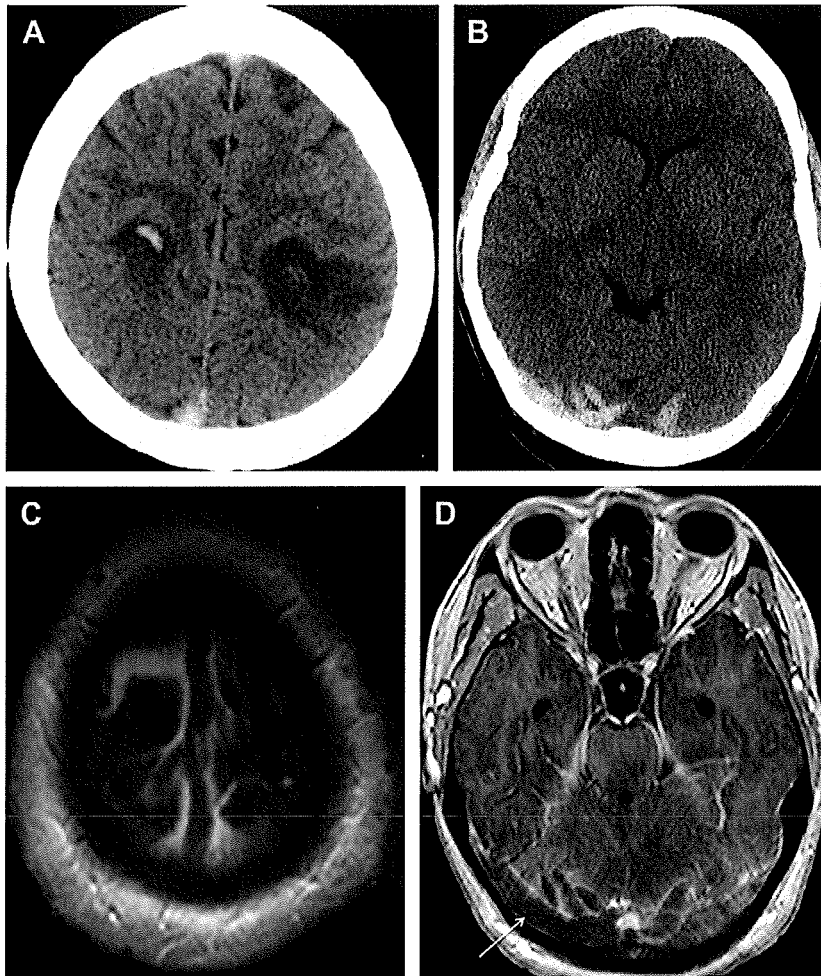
Venous hemorrhagic infarction. Axial noncontrast CT image (A) shows biparietal intraparenchymal hemorrhages with surrounding hypoattenuation consistent with vasogenic edema. Hyperattenuation within the superior sagittal sinus suggesting hemorrhagic infarcts secondary to dural sinus thrombosis. A more caudal noncontrast axial CT image (B) demonstrates linear hyperattenuation along the transverse sinuses and cortical veins consistent with dural sinus and cortical venous thromboses. Postgadolinium axial 3-dimensional magnetized-prepared rapid gradient echo images (C, D) confirm the presence of superior sagittal sinus, transverse sinus (arrow), and cortical venous thrombosis with filling defects found in those locations.
